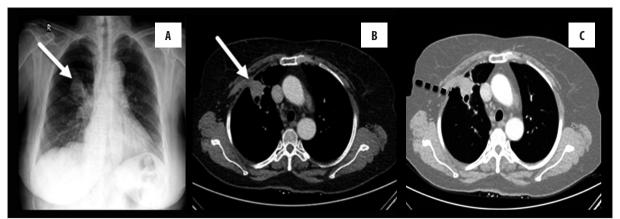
(A) Chest x-ray shows opacity with a lobulated contour in the upper mid zone (white arrow); (B, C) contrast enhanced axial CT scan of the thorax demonstrating a pleura-based lobulated mass (white arrow) in the anterior segment of the right upper lung lobe with central cavitation (black dashed arrow).
